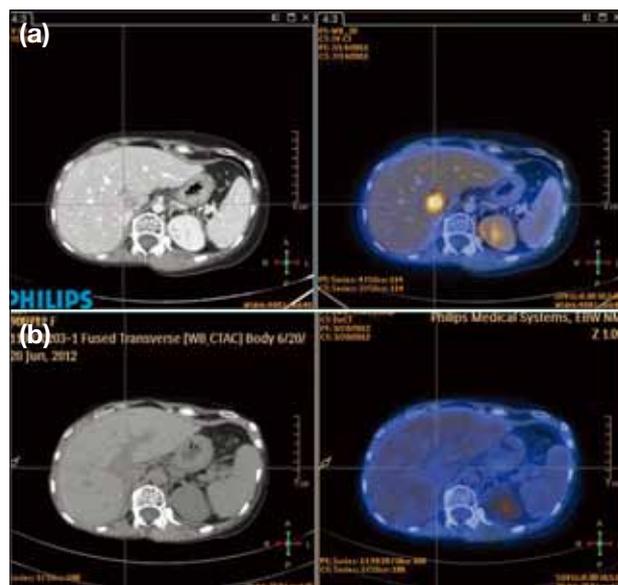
Computed tomography images from (a) July 2011 and (b) June 2012 showing excellent tumour regression after four cycles of carboplatin, pemetrexed, and bevacizumab followed by pemetrexed and bevacizumab maintenance therapy.
